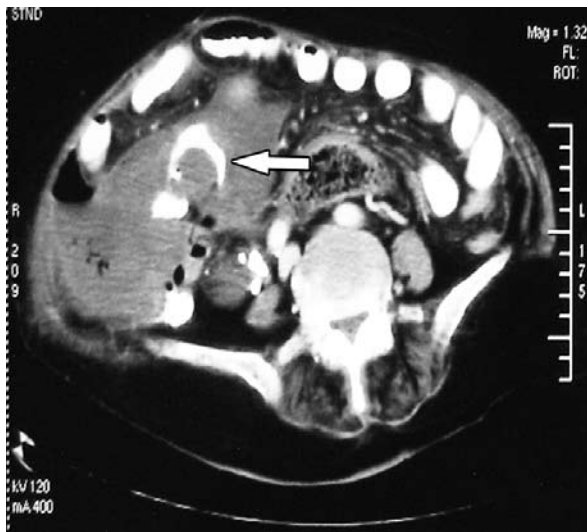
Computed tomography cut of the tumor in the right iliac fossa.
